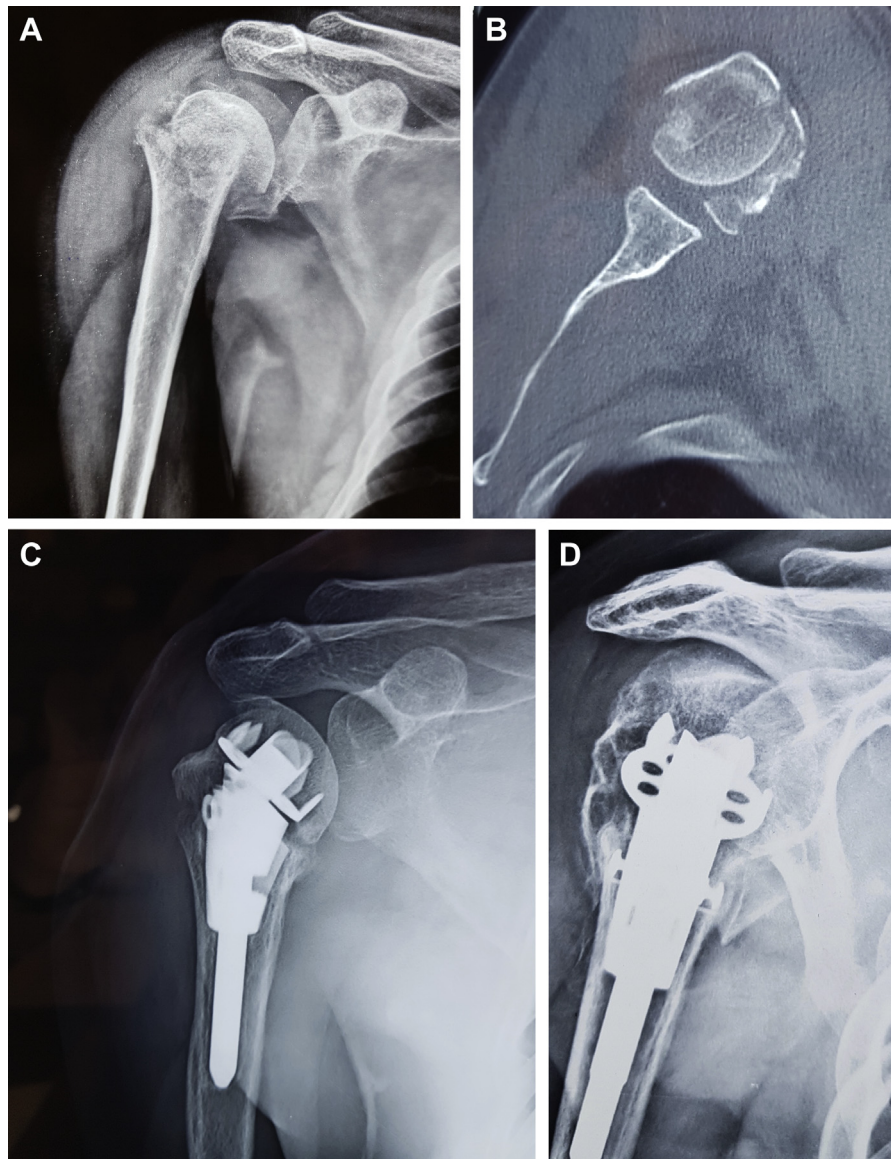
(A) Preoperative anteroposterior radiograph showing displaced 4-part proximal humeral fracture. (B) Axial-cut computed tomography scan showing displaced 4-part proximal humeral fracture with small head fragment. (C) Anteroposterior radiograph at final follow-up showing well-reduced and -healed fracture. (D) Radiograph showing well-healed fracture.
